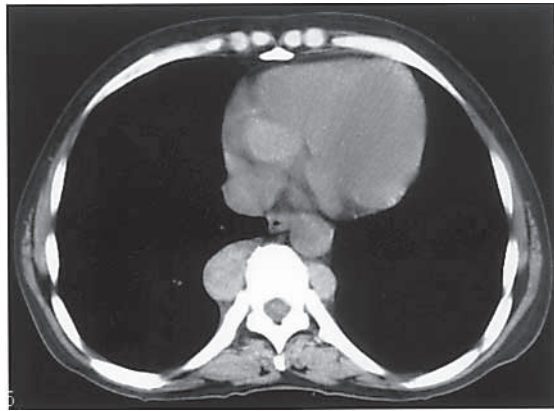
Thoracic CT showed bilateral paravertebral masses with smooth margin and isodensity to muscles.
